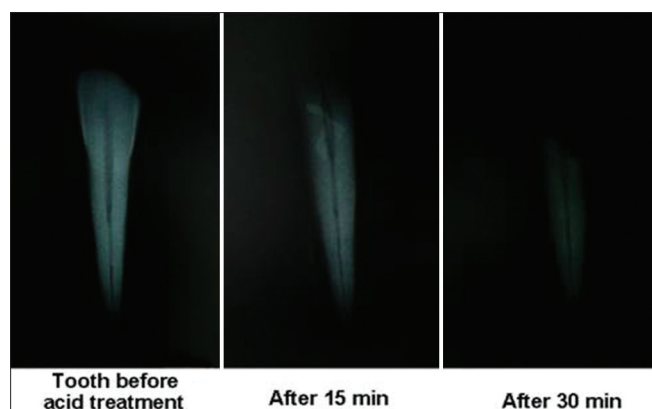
Radiographical appearance of teeth treated with conc. HNO_3 at different interval
